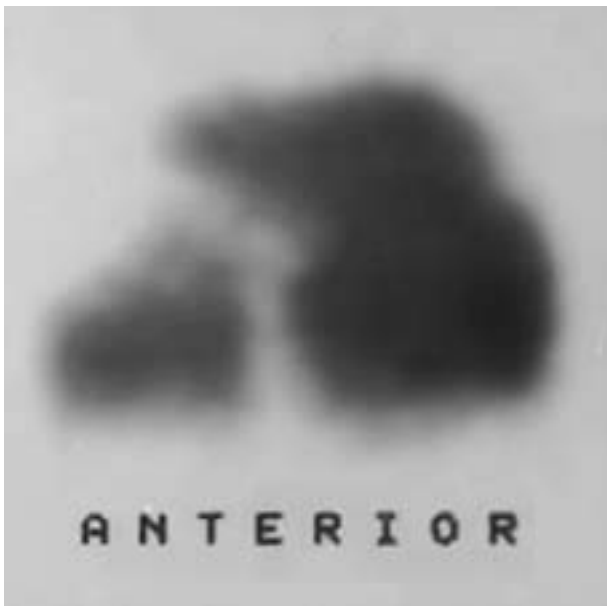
Lung perfusion scintigraphy.
